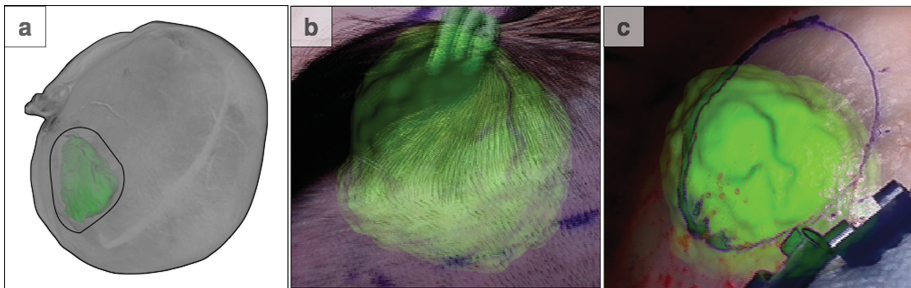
Case 3: (a) 3D rendered MRI and segmented tumour virtual patient model, showing position of patient head and location of the craniotomy planned. (b) Tumour projected onto the scalp, due to a poor registration results in IBIS the surgeon used traditional the Medtronic system to trace the tumour. (c) A discrepancy can be seen (1–2 cm) between the outlined tumour, which was drawn using the Medtronic system, and the AR overlay given in IBIS.
